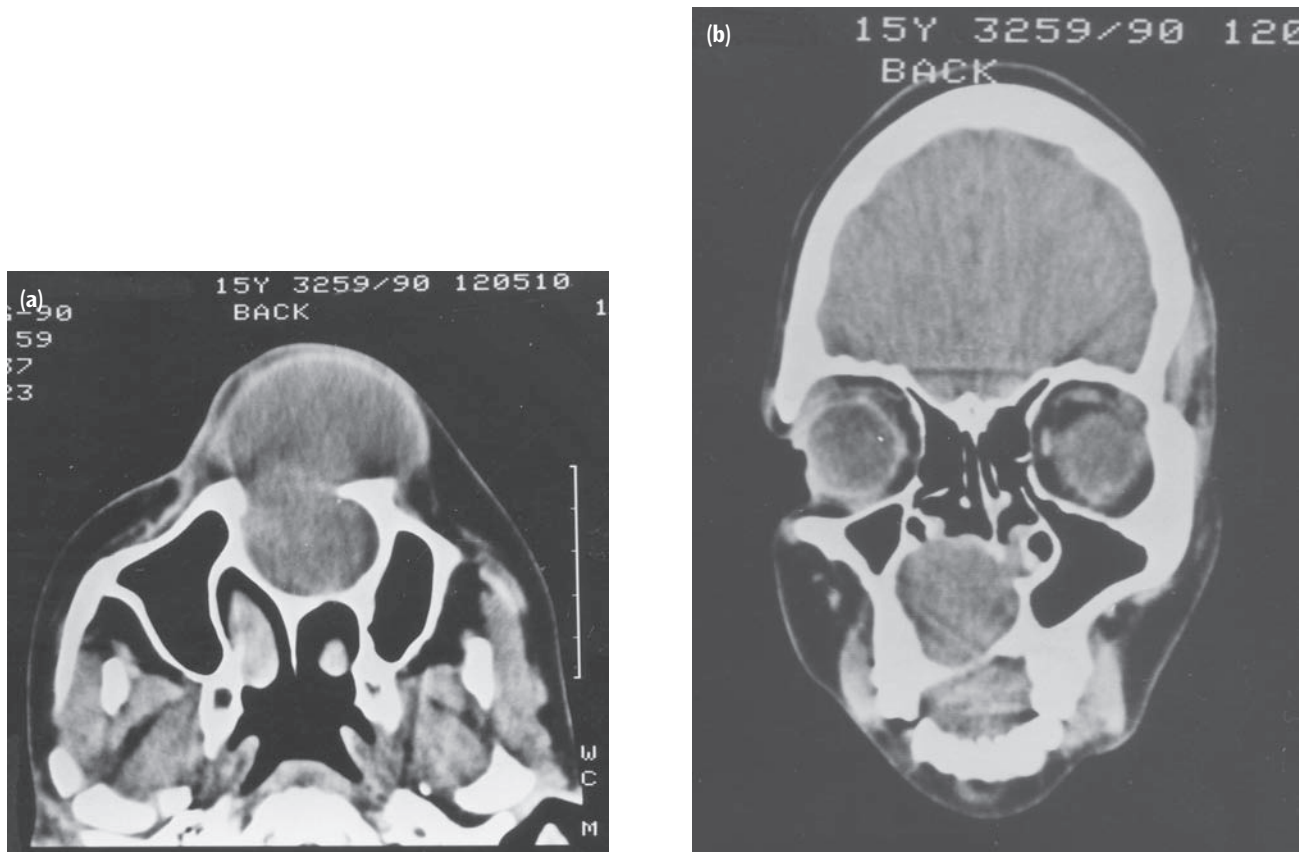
Nasopalatine duct cyst. (a) Axial CT scan showing a well-defined mass extending through the palatal ridge. (b) Coronal scan showing bowing of the hard palate and extension of the mass into the nasal cavity. (Courtesy of Professor J. Lownie.)
